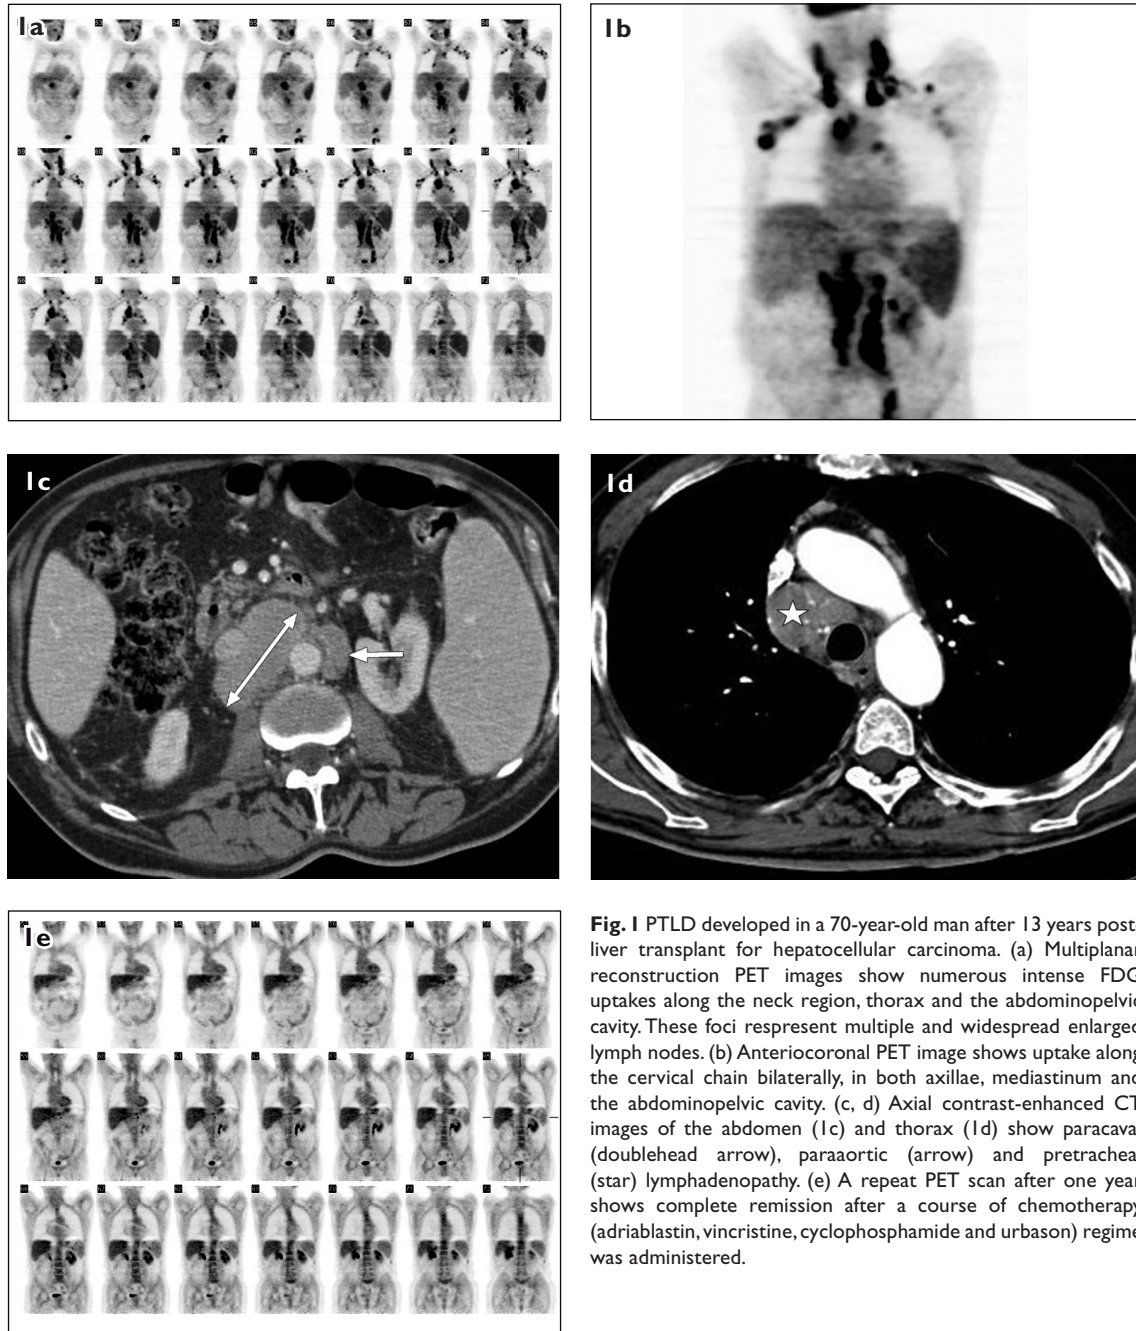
PTLD developed in a 70-year-old man after 13 years post-liver transplant for hepatocellular carcinoma. (a) Multiplanar reconstruction PET images show numerous intense FDG uptakes along the neck region, thorax and the abdominopelvic cavity. These foci represent multiple and widespread enlarged lymph nodes. (b) Anteriacoronal PET image shows uptake along the cervical chain bilaterally, in both axillae, mediastinum and the abdominopelvic cavity. (c, d) Axial contrast-enhanced CT images of the abdomen (1c) and thorax (1d) show paracaval (doublehead arrow), paraaortic (arrow) and pretracheal (star) lymphadenopathy. (e) A repeat PET scan after one year shows complete remission after a course of chemotherapy (adriablastin, vincristine, cyclophosphamide and urbason) regime was administered.
